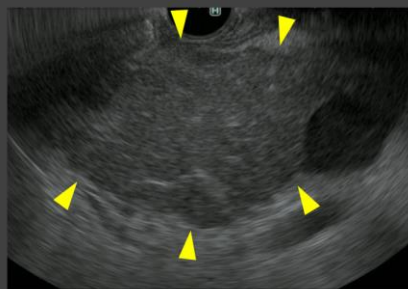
Endoscopic ultrasonography showed diffuse pancreatic enlargement, with prominent swelling of the pancreatic head (arrowheads). Hyperechoic foci and strands, as well as lobularity, were observed in the pancreatic parenchyma.
